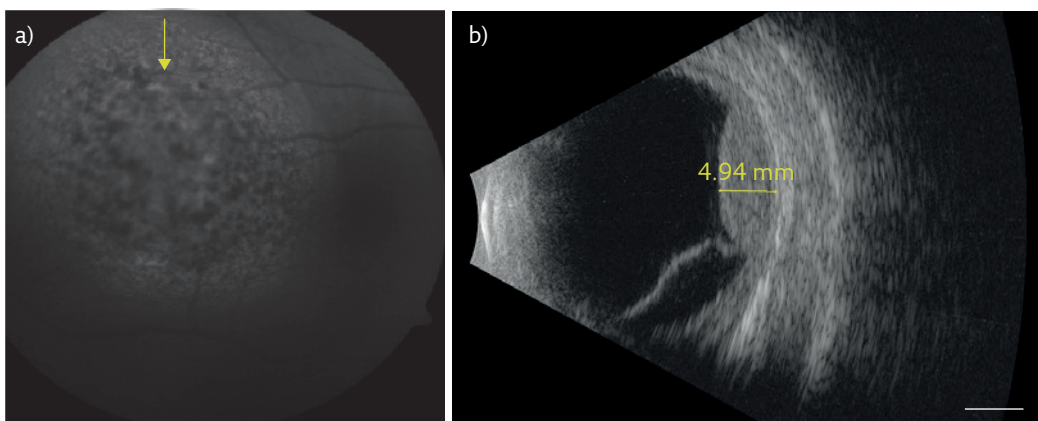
a) Red-free funduscopy of the right eye. The arrow indicates pathological findings in the choroid. b) Ultrasonography of the right eye, showing measurement of the choroidal mass. Scale bar=5 mm. Images from April 2018, courtesy of Z. Hendrickson, Clinic of Ophthalmology, 1st Medical Faculty of Charles University and General University Hospital, Prague, Czech Republic.
